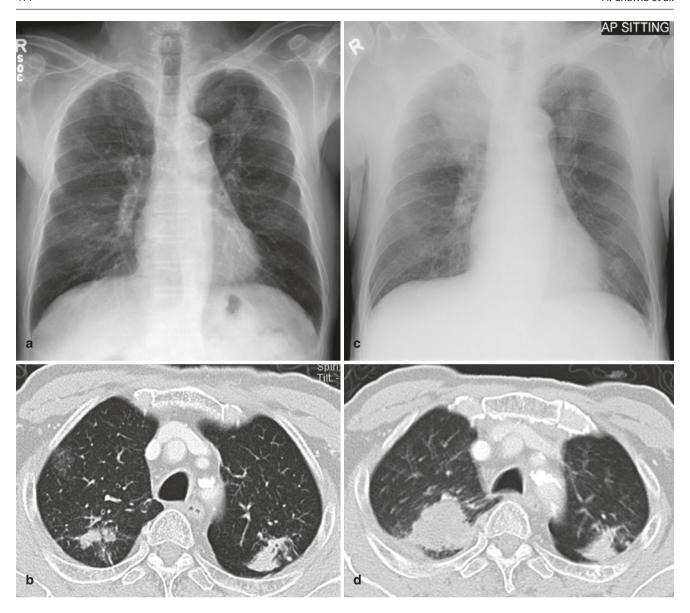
Coal worker pneumoconiosis with PMF developing lung cancer. (a) Frontal chest radiograph shows bilateral upper lung opacities. (b) CT image shows opacities in bilateral posterior upper lungs. (c)
